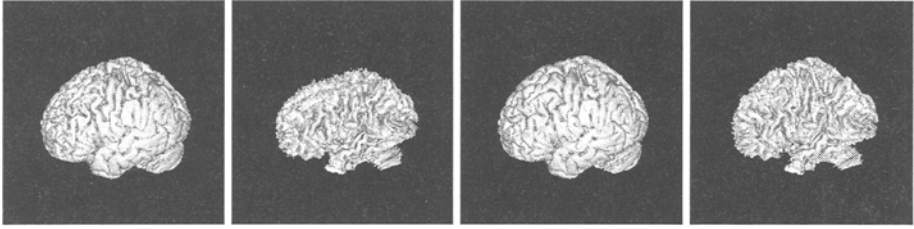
3D rendering of grey matter and white matter segmentations of a T1-weighted MR image of the head. From left to right: grey matter and white matter segmentation obtained with the EM algorithm without bias correction; grey matter and white matter segmentation obtained with the extended EM algorithm
